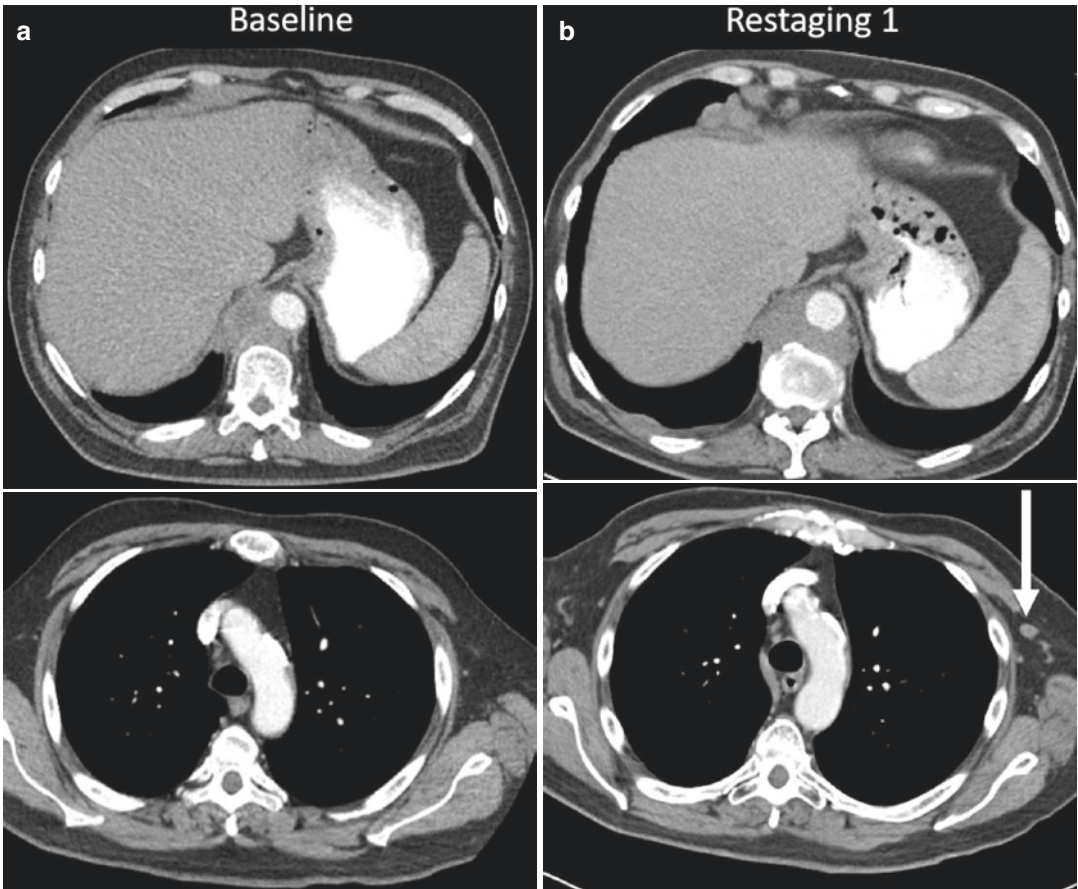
Diffuse large B cell lymphoma. (a) Baseline CT scan prior to starting nivolumab showed abnormal soft tissue surrounding the descending aorta. No abnormal axillary lymph nodes were seen. (b) On the first restaging CT scan 12 weeks after starting nivolumab, the soft tissue
